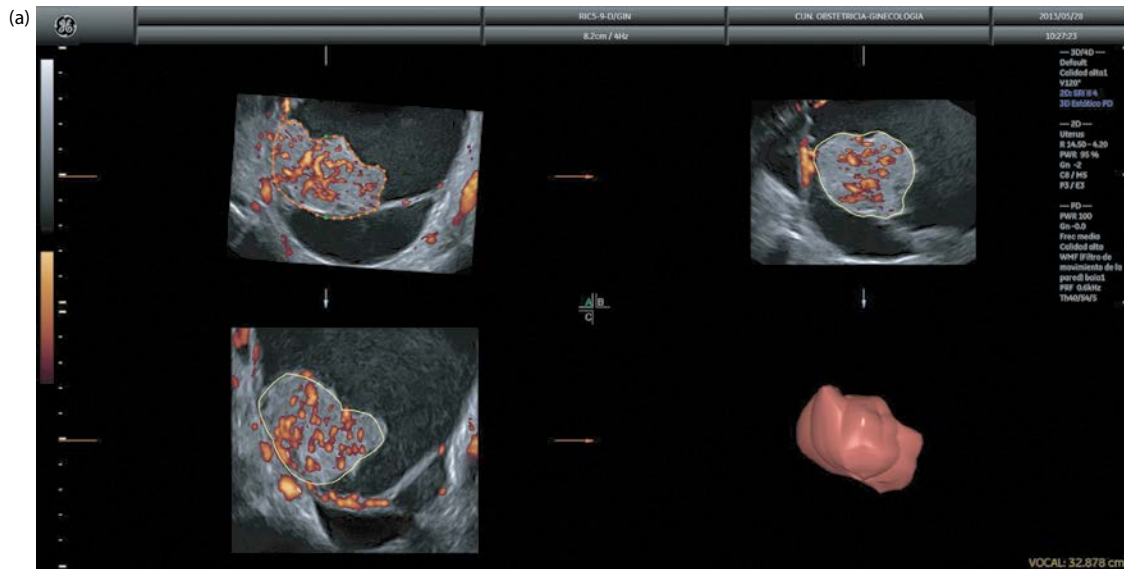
Three-dimensional ultrasound of a multilocular-solid mass. The solid component volume has been calculated (a), and within this solid component, the 3D vascular indices can be calculated (b).
